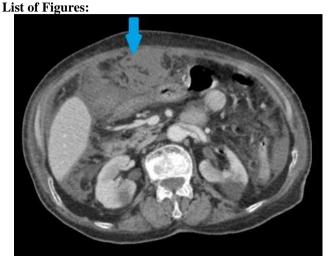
An axial section of an abdominal CT scan after injection of contrast, showing a fatty mass with concentric strands interposed between the colon and the anterior abdominal wall.
